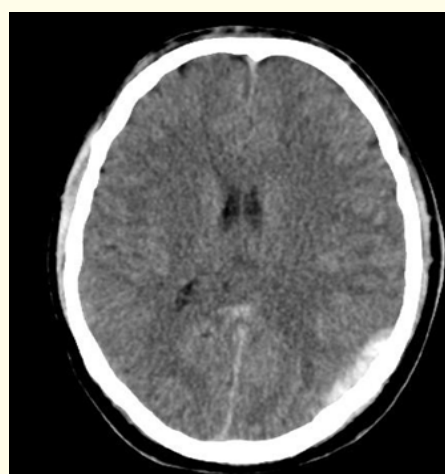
Axial CT section shows epidural hematoma.
